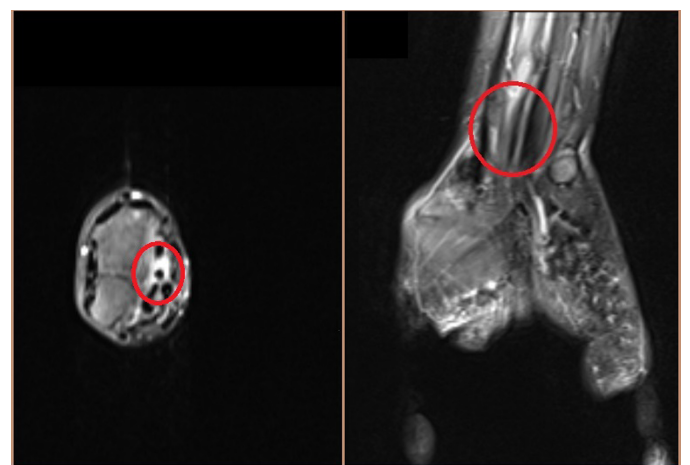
Magnetic resonance images showing alterations consistent with tenosynovitis.
